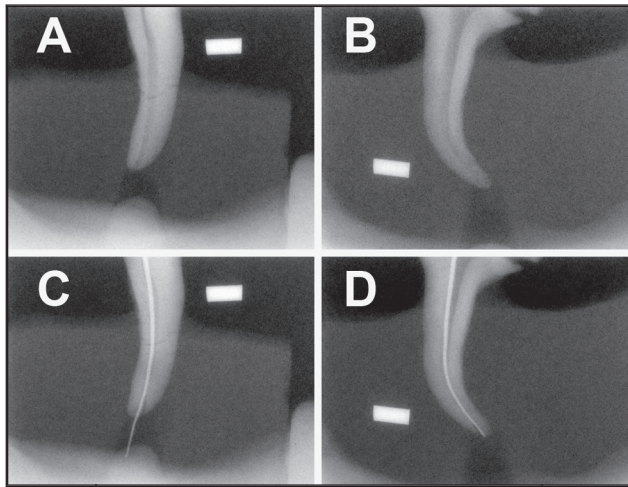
Two representative examples from the present study showing zip formation. Preoperative radiographs (A and B). Post-instrumentation radiographs of A and B (C and D, respectively). A precurved gutta-percha cone has been used to enhance contrast along the canal wall.
